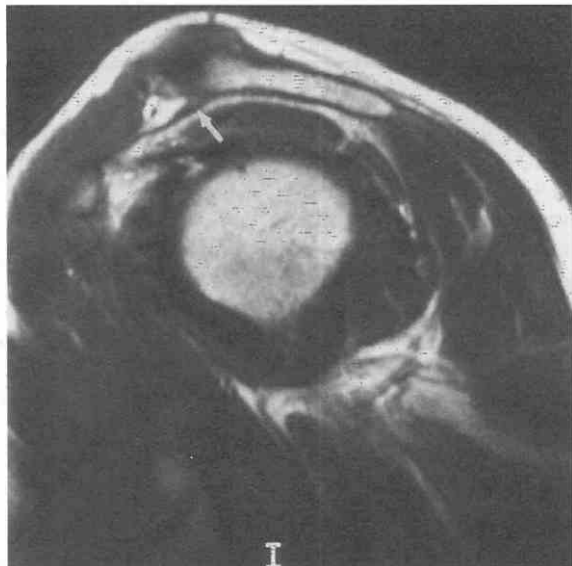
Spur. Fast spin-echo, T2-weighted sagittal oblique image. A spur containing marrow projects from the undersurface of the otherwise flat acromion at the attachment site of the coracoacromial ligament (arrow). The conjoint tendons of the short head of the biceps brachii muscle and the coracobrachialis are seen originating from the coracoid process.
